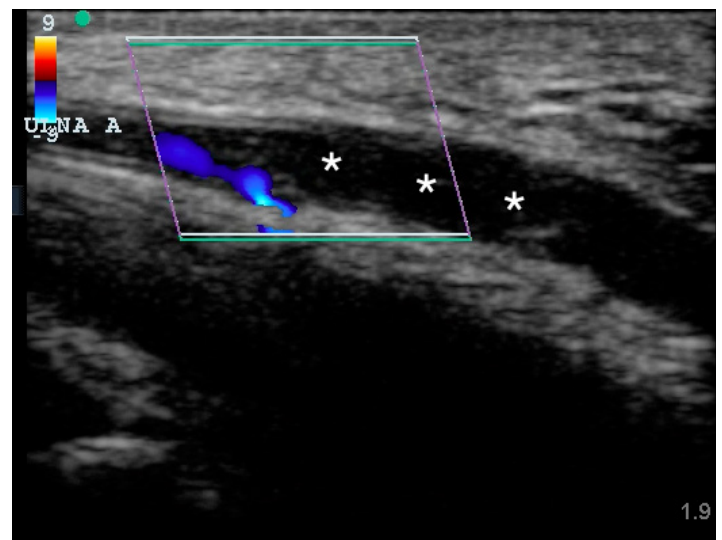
Ultrasound image of the distal ulnar artery in longitudinal plane noting reduced flow proximal to the thrombus with absent flow distally and echogenic thrombus (asterisks) within the lumen.
